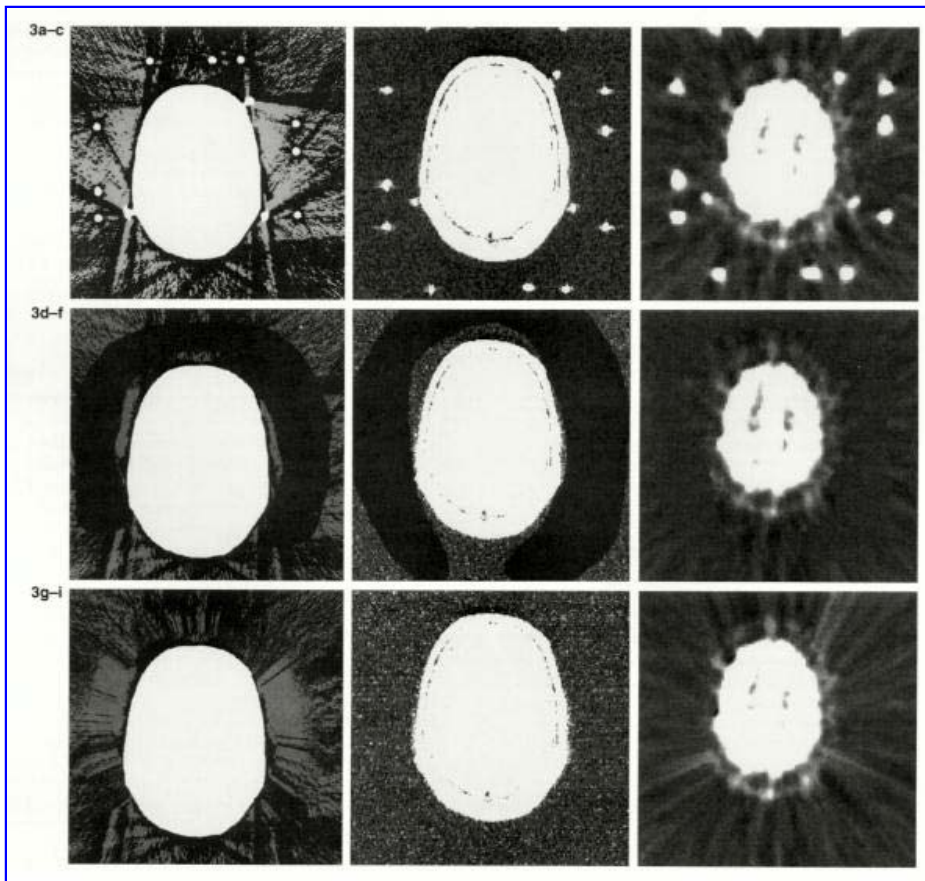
Removal of fiducial markers and stereotactic frame. The top row (a-c) shows sample original image slices from CT (a), MR (b), and PET (c). The stereotactic frame (bright circular spots toward the edge of the image) and fiducial markers (three bright spots near the head) are clearly visible in all three modalities. The window and level have been set to show the background artifacts. The middle row shows the same image slices after the region R has been outlined and zeroed. All trace of the stereotactic frame and fiducial markers has been removed. The bottom row (g-i) shows the image slices after reconstruction of the background in the region R . For MR, the replaced area is indistinguishable from the rest of the background. For CT and PET, there are slight discontinuities in the direction of the stripes, but the intensity changes relatively smoothly.
